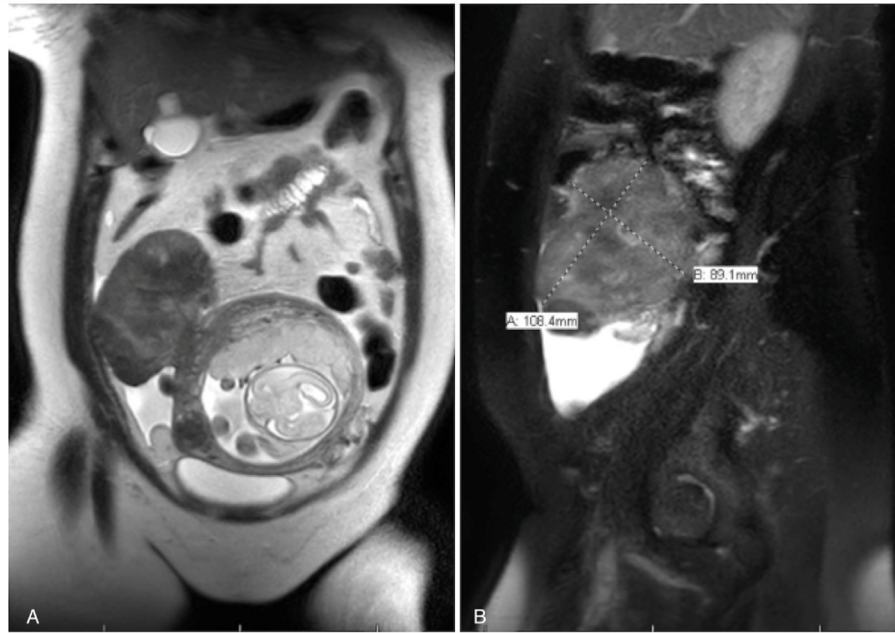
MRI pelvis demonstrating a 11 cm × 10 cm × 9 cm pedunculated fibroid arising from the right lateral aspect of the uterine fundus. A. Coronal position; B. Sagittal position.
